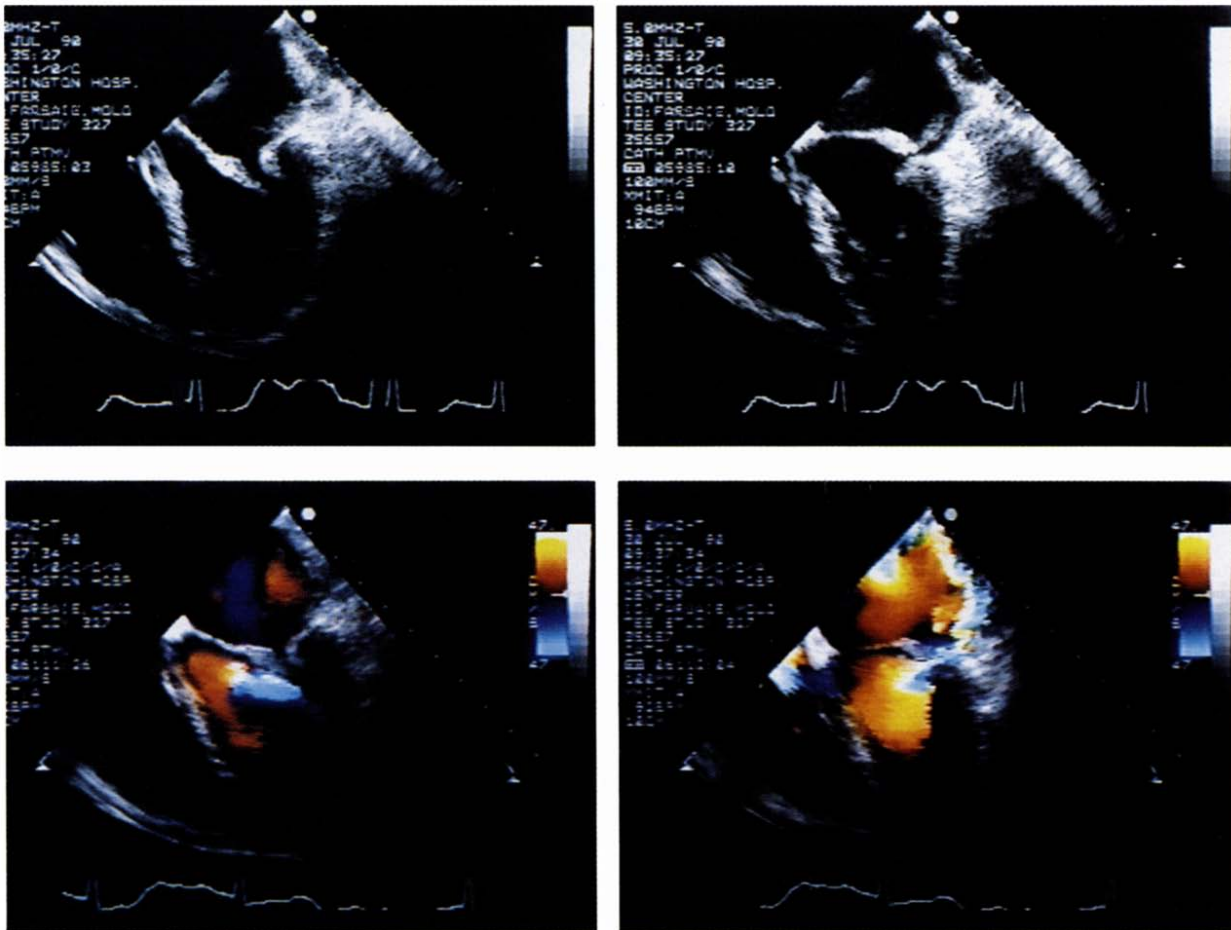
Sequence of frames from a transesophageal echocardiogram obtained immediately before mitral valve replacement in a patient with severe mitral regurgitation after Inoue balloon valvuloplasty. Upper panel demonstrates prolapse of the posterior leaflet with an attached chord into the left atrium during systole. Lower panel shows a central and septally directed Doppler color flow jet of severe mitral regurgitation.
